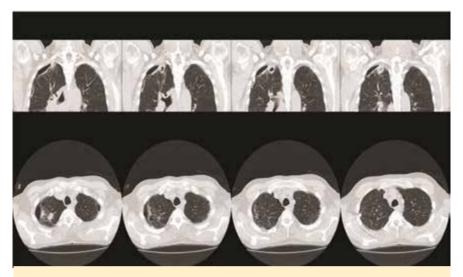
CT scan revealing bilateral apical sub-pleural bullae, paraseptal emphysema and a cavitary nodular lesion in the right apical region.
